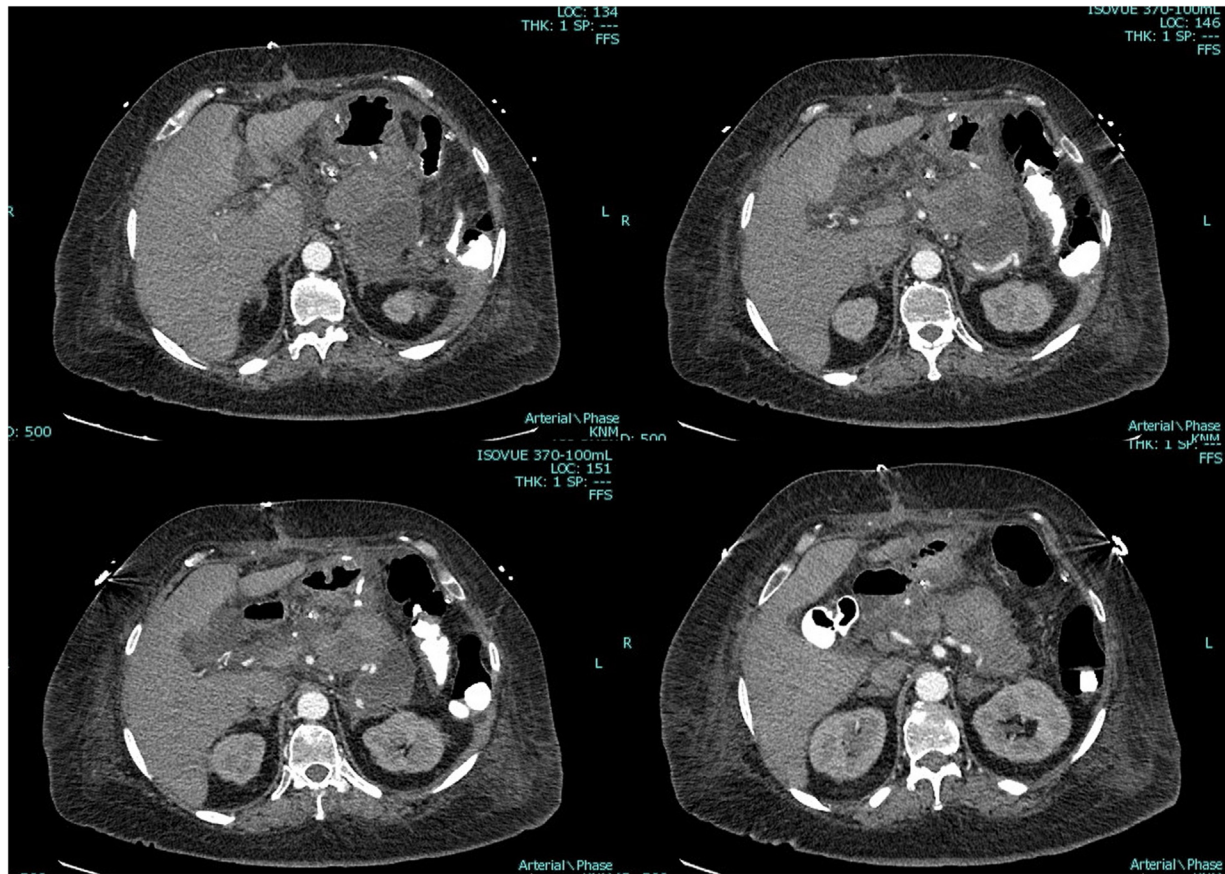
Postoperative computed tomography (CT) angiogram showing thrombosed splenic artery pseudoaneurysm and pseudocyst.
